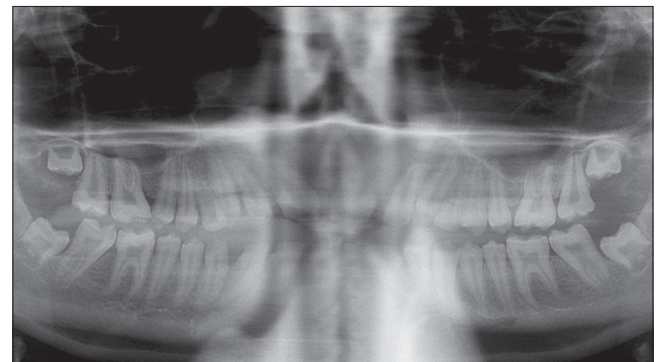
Panoramic radiograph of the 16-year-old sibling revealing thin enamel layer and abnormalities of cusp formation
